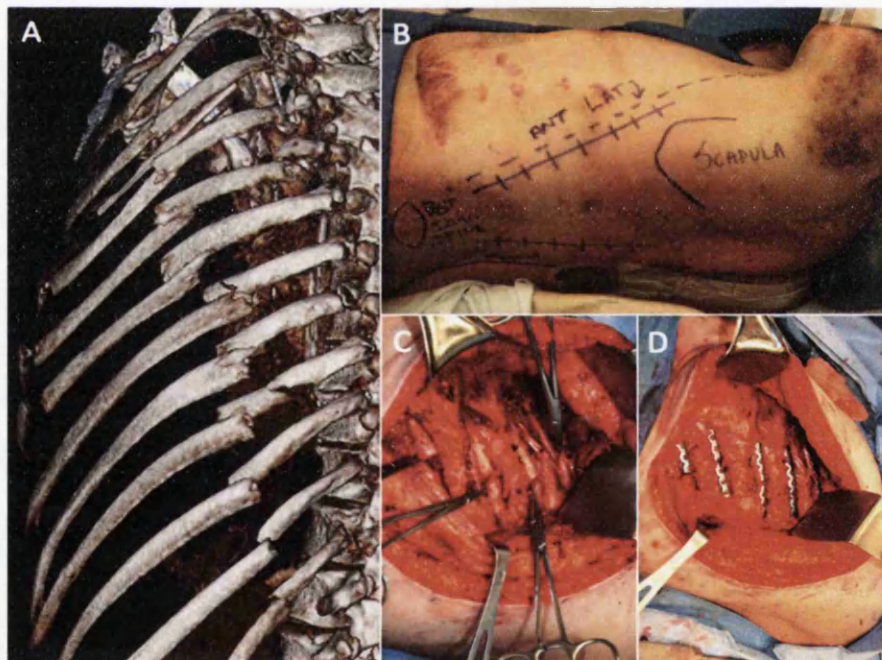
Stages of surgical rib fracture stabilisation. Reproduced with permission from Bottlang et al (2013). (A) CT reconstruction is crucial for fracture visualization. (B) Intra-operative planning of left thoracotomy overlying the flail segment with latissimus sparing exposure. (C) Exposure of rib fracture with preservation of periosteum. (D) Surgical stabilization with anatomic plates.
